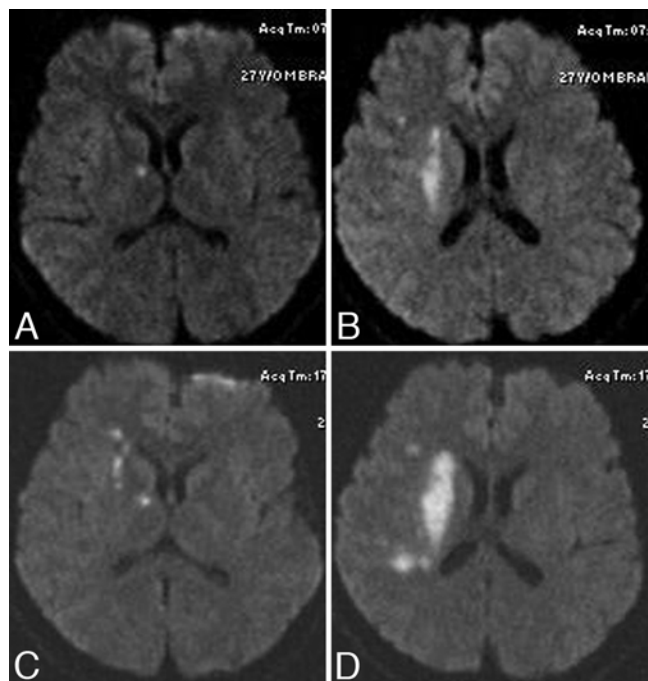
Case 1. Comparably selected axial diffusion weighted MR images obtained on Day 1 (A and B) and Day 2 (C and D) after presentation demonstrate increasing areas of ischemic injury matching the patient's symptomatic clinical progression.
